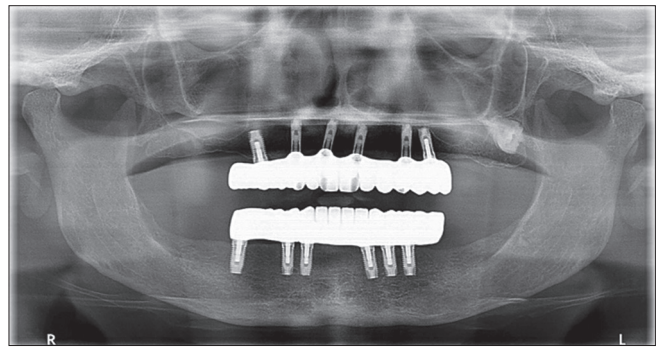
Panoramic radiograph taken after final prostheses with dynamic abutments used for the four ante-rrior maxillary implants
